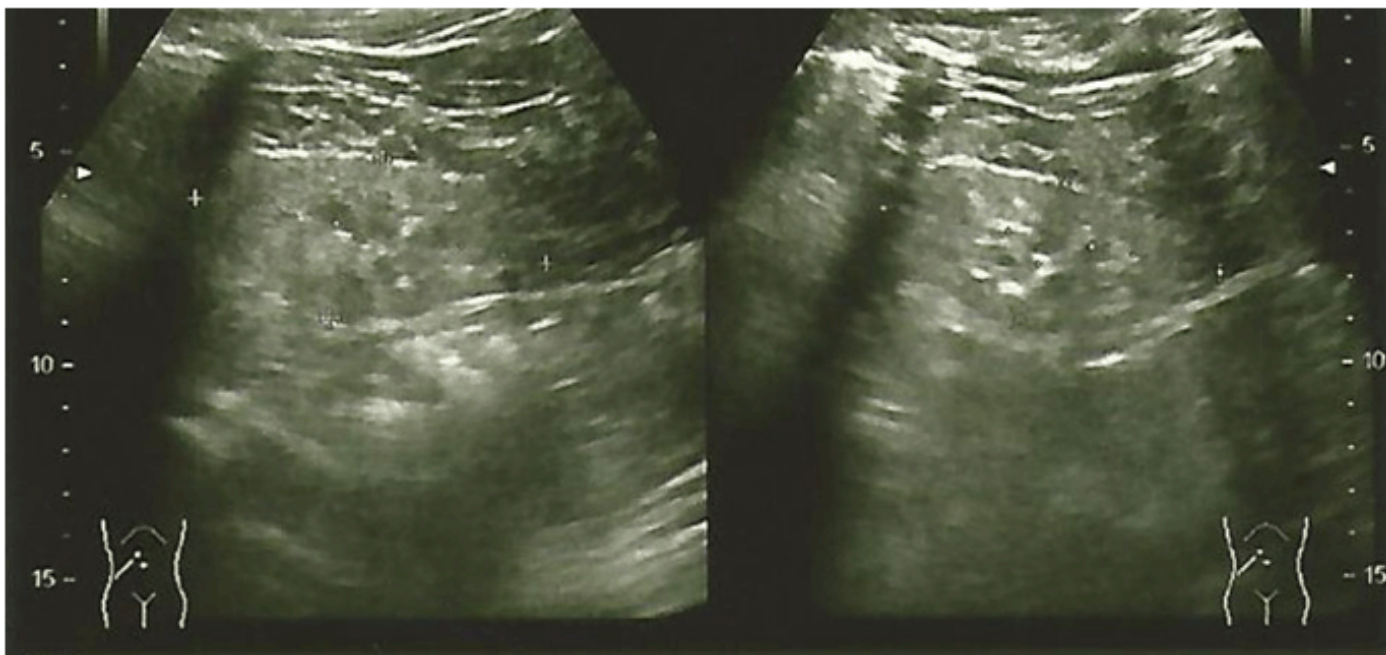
Gray scale ultrasound image on the right and left kidneys, where both kidneys were decreased in size; atrophied secondary to diabetic nephropathy.
